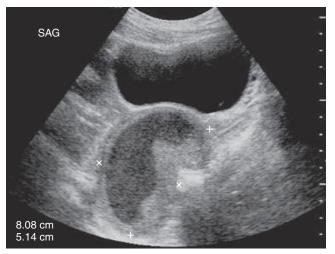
Transabdominal sonogram of the uterus.
